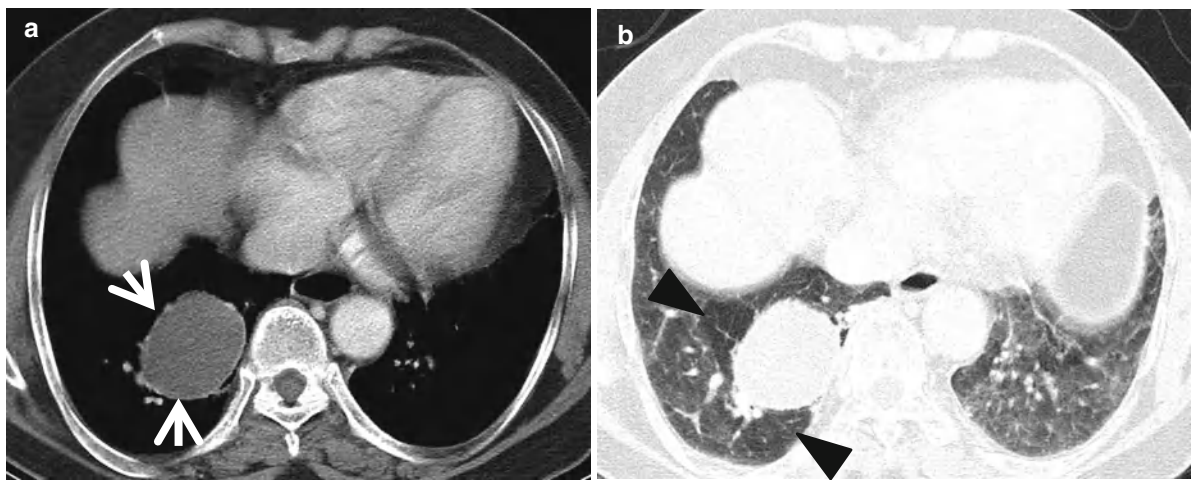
Intrapulmonary bronchogenic cyst in a 61-year-old woman. (a) Mediastinal window image of enhanced CT scan (5.0-mm-section thickness) obtained at level of liver some shows a 45-mm-sized well-defined homogeneous low-attenuation (9 HU) lesion (arrows) in right
